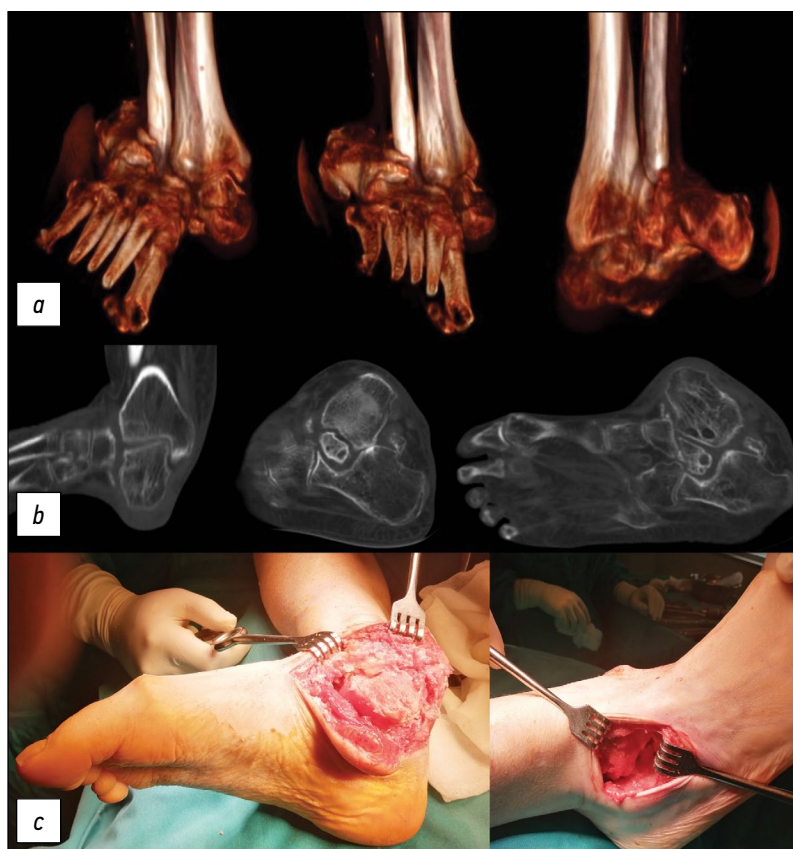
Preoperative CT with 3D reconstruction (a and b) and intraoperative clinical images of the medial and lateral approaches (c).
